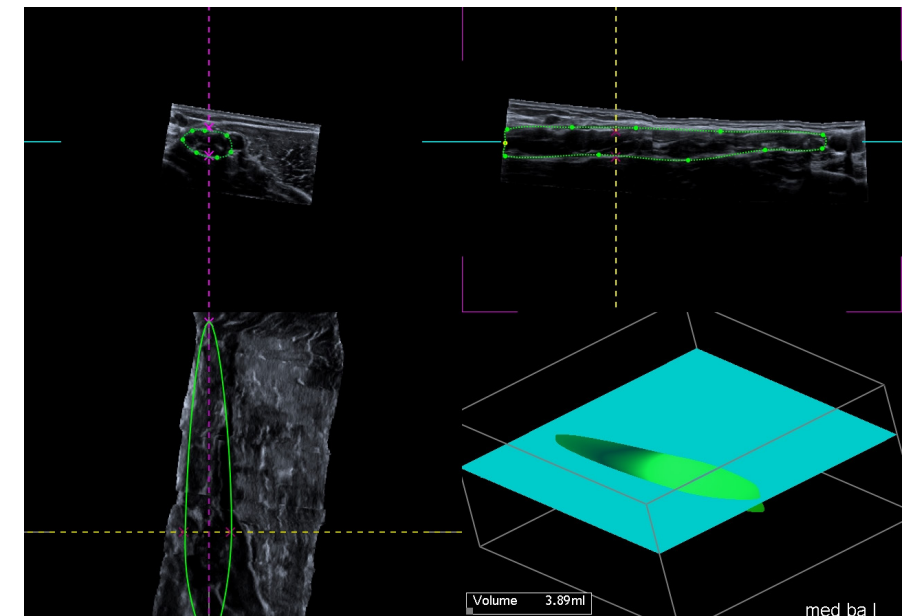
Image obtained with 3D-nerve ultrasound in a patient with neurofibromatosis type 1 and a plexiform neurofibroma in the left median nerve. The upper left panel shows the regular transverse sonographic image with the nerve measured within the hyperechoic rim. The right upper panel shows the simultaneously obtained longitudinal view of the median nerve. In the left lower corner a coronal view of the same nerve is shown, and in the right lower panel a 3D reconstruction of the region of interest with a calculated volume of the nerve (created by the measurements performed in transversal and longitudinal plane). At this moment optimization of the visualization of the coronal plain of view and the 3D-reconstruction is still necessary. Volumetric measurements are currently still based on an assumed spherical shape, but development of a tool to determine volume with an assumed cylindrical shape (which is regularly the shape of nerves) is ongoing to be able to perform volumetry of the nerve with ultrasound.
